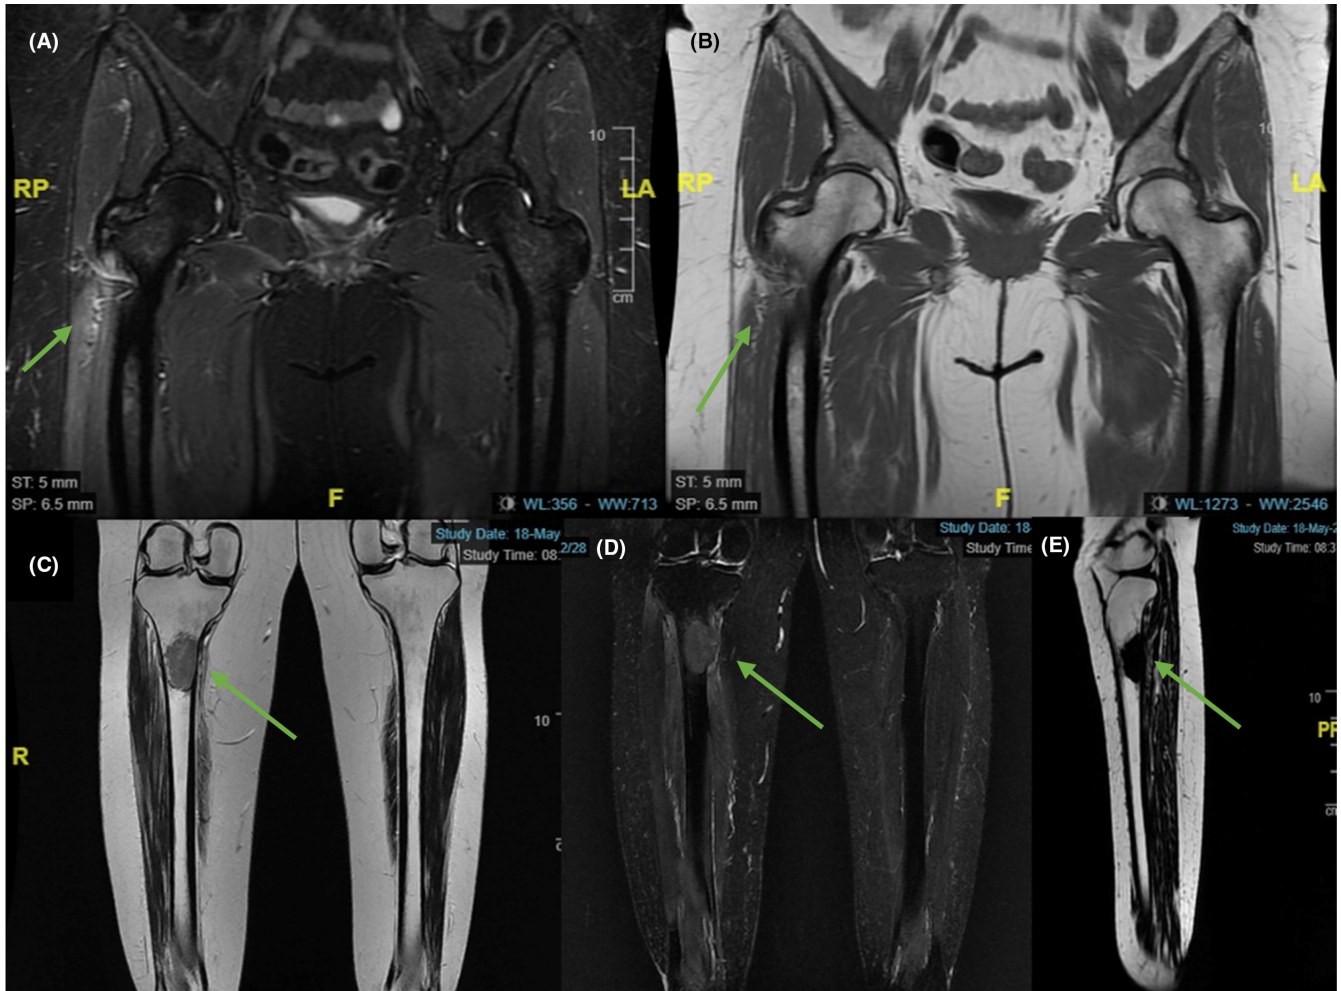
(A) Pelvis MRI coronal STIR sequence, (B) Pelvis MRI T1-FSE sequence revealing a focal lesion in the lateral and inferior aspect of the right greater trochanter, which replaces the bone marrow, with apparent cortical disruption and associated bone marrow edema, which presents diffuse and homogeneous enhancement after the administration of intravenous contrast medium (green arrows). (C) MRI lower leg coronal T2 images, (D) MRI lower leg coronal STIR FSE sequence, (E) MRI lower leg sagittal DP FSE sequence identifying in the proximal diaphysis of the right tibia, of intramedullary location, a lesion that generates bone marrow replacement, with compromise of the posterior cortical of the tibia and exophytic component. The diameters of the lesion are longitudinal: 50.2 mm, transverse: 25 mm and anteroposterior 33 mm, its upper border is 44 mm from the tibial eminence and its lower margin is 26.6 cm from the tibiotalar joint as reference points (green arrows).
